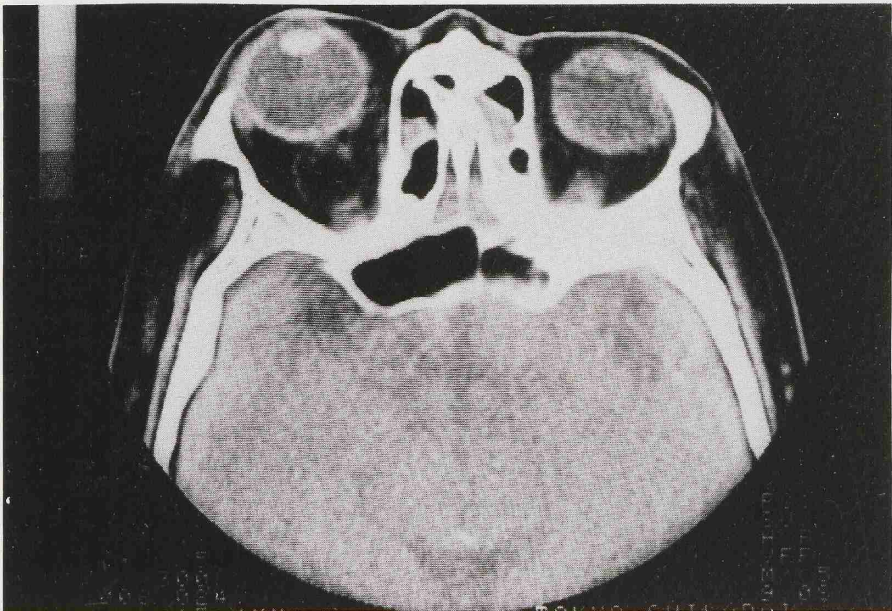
CT findings indicating retrobulbar bleeding (Case 2).
